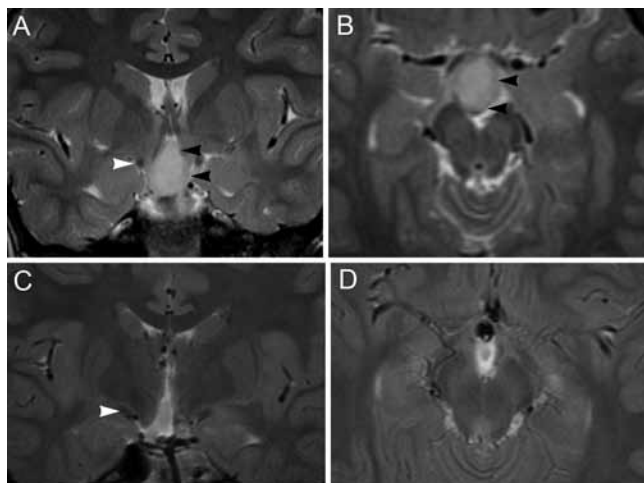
Preoperative (A and B) and postoperative (C and D) T2-weighted MR images of a large Type II HH completely resected via the transcallosal approach. The HH is hyperintense (black arrowheads) compared with the normal surrounding structures including the optic tract (white arrowheads).
